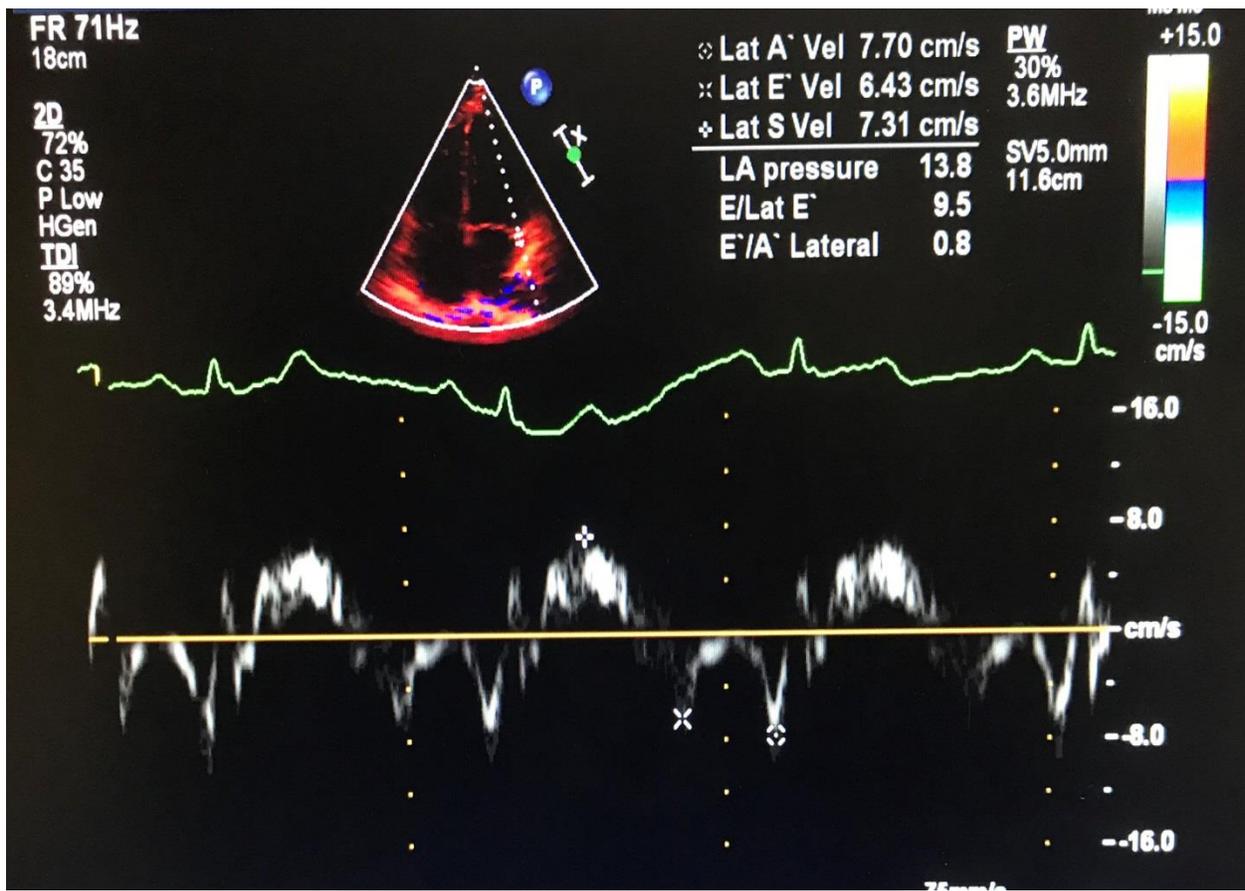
Tissue Doppler imaging of lateral segment of LV during rest.
